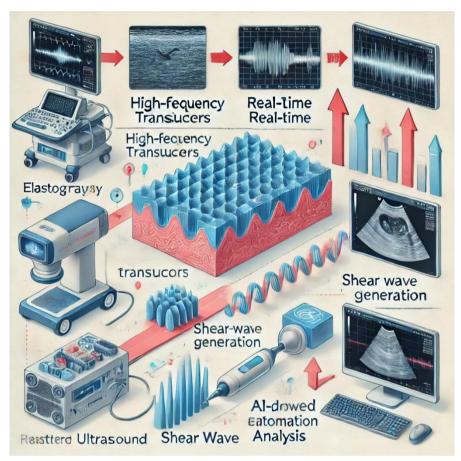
Developments in Ultrasound Elastography Technology.
